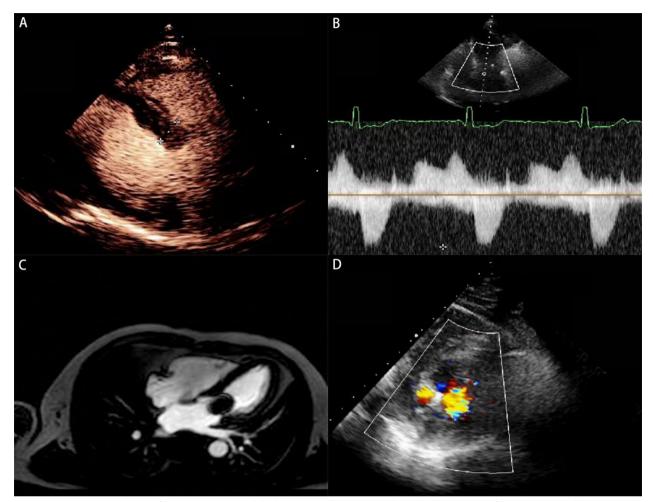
Postoperative evaluation of interventricular septal thickness, LVOT obstruction and MR. A UCG shows significant reduction in basal interventricular septal hypertrophy. B Resting LVOT peak pressure drops to 14 mmHg. C MRI evaluation shows significant reduction in basal interventricular septal hypertrophy. D UCG shows significant reduction in MR
